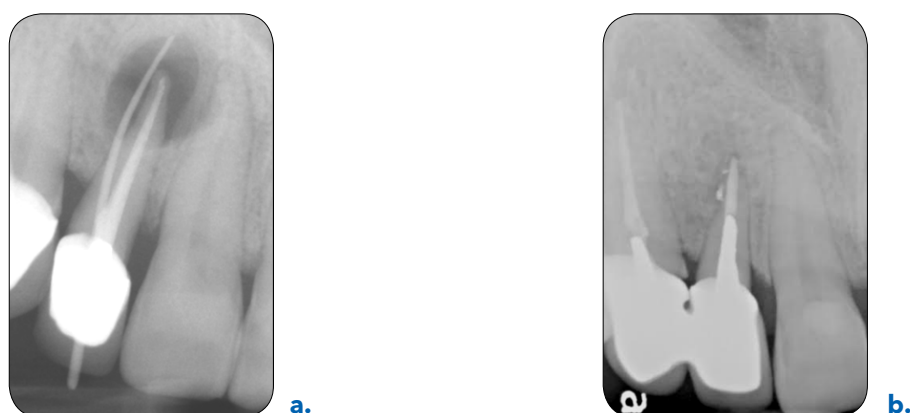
Radiograph tooth #12
